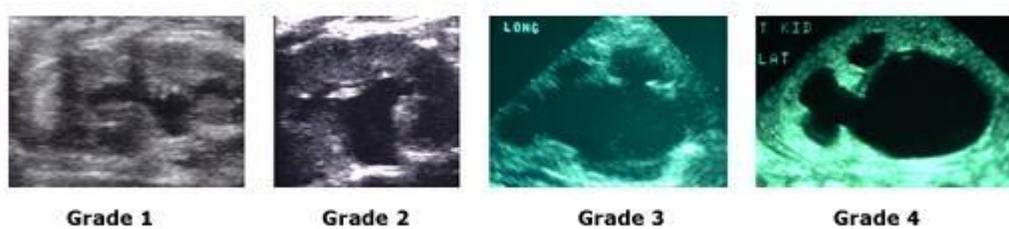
Ultrasound pictures of the various grades of hydronephrosis. (Source: Ref⁶⁶)
